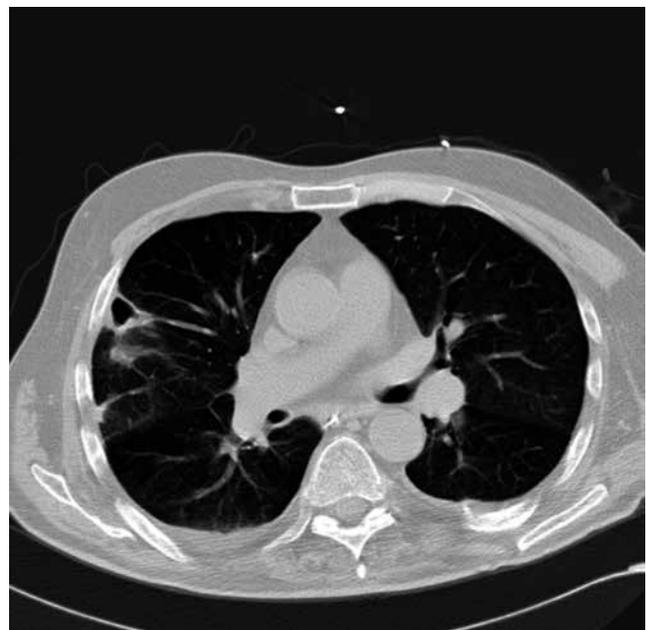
Repeated chest-CT after a 2 weeks, showing a small cavitary lesion in the right upper lobe.
